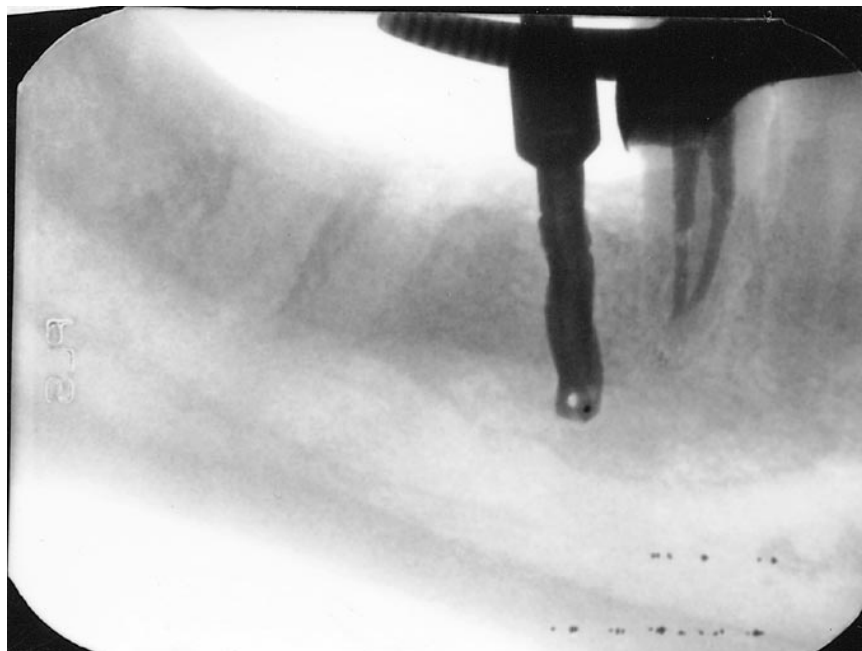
Periapical x-ray with surgical pilot drill in place.
